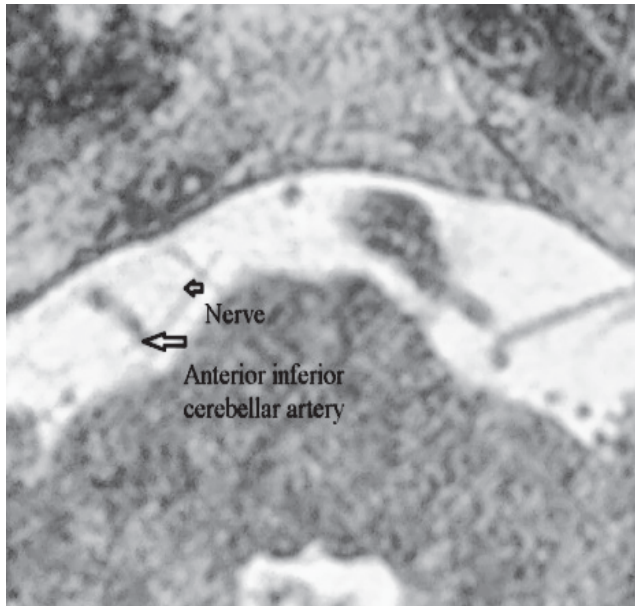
Axial 3D T2 Drive MR image.
